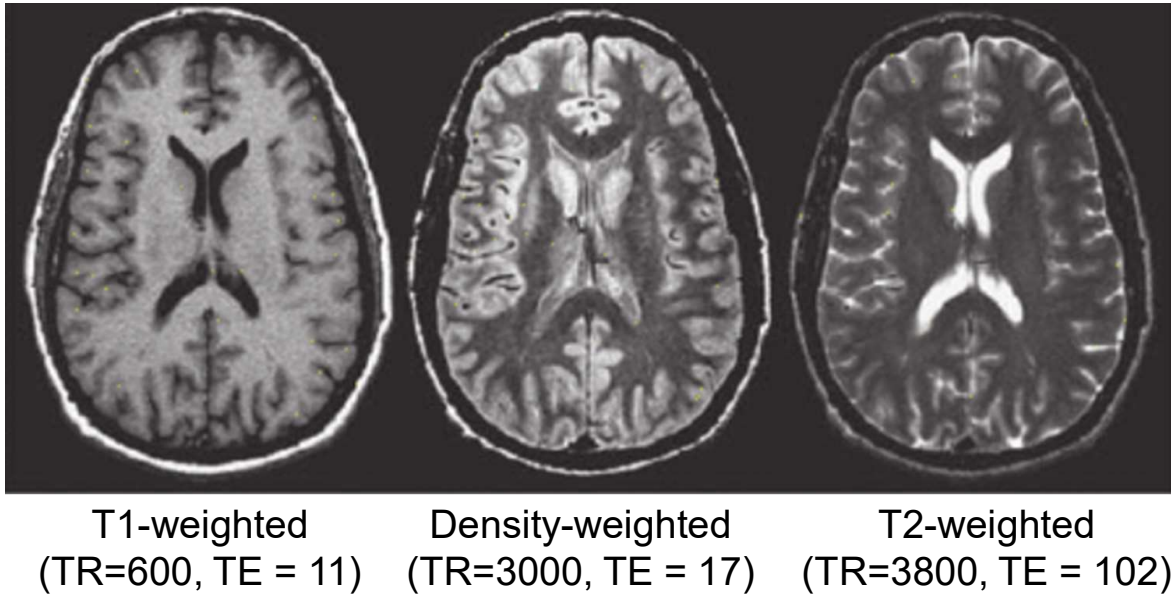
Three conventional MR sequences namely T1-w, DWI, and T2-w images. Adapted from [86].
